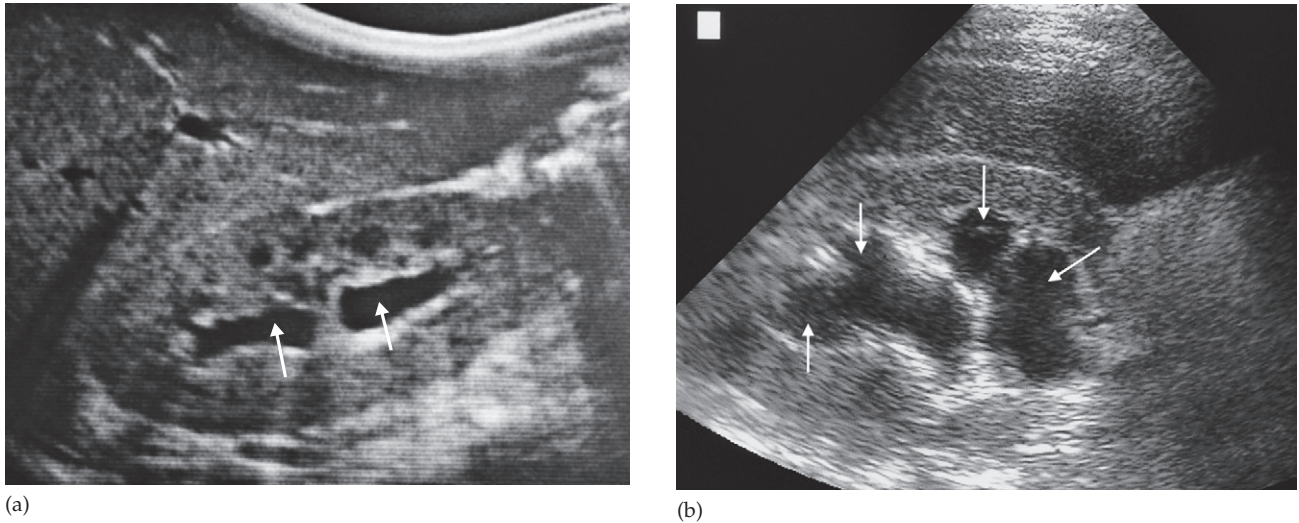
Dilatation of the pelvicaliceal system. (a) Longitudinal ultrasound scan of the right kidney showing spreading of the central echo complex of the dilated collecting system (arrows). (b) Here the dilatation of the calices is greater (arrows).
